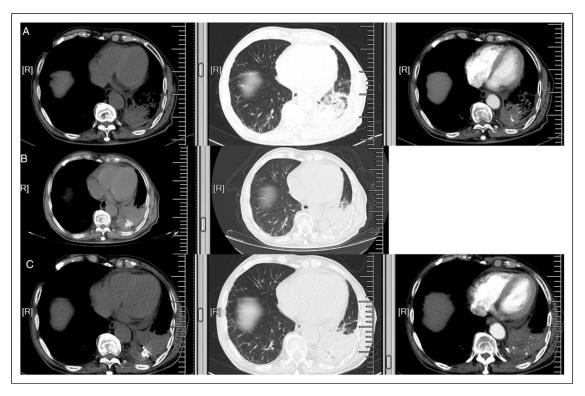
The lesion on chest CT during I-125 seeds, chemotherapy and targeted therapy. (A) The maximal cross-section of lesion was 64 mm*41 mm on March 4th, 2021. (B) The maximal cross-section of lesion was 64 mm*65 mm on April 19th, 2021. (C) The maximal cross-section of lesion was 64 mm*65 mm on April 19th, 2021. (C) The maximal cross-section of lesion was 64 mm*65 mm on April 19th, 2021.
